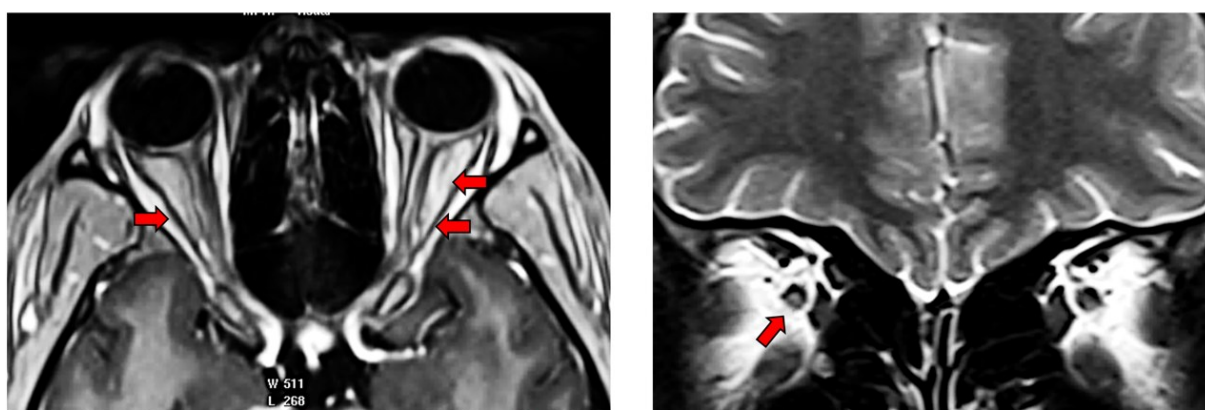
MRI Images of examples of optic neuritis on dedicated Optic Nerve sequences in cases of NMOSD
